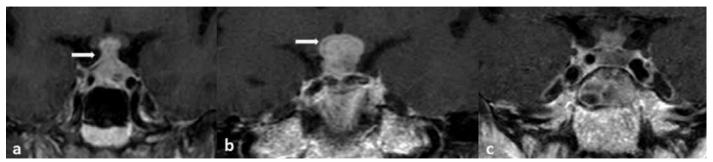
a) Pituitary magnetic resonance imaging of the patient on admission, thickened pituitary stalk (arrow) and heterogenic sellar enlargement, b) magnetic resonance imaging of the recurrent pituitary lesion extending to hypothalamus (arrow), c) magnetic resonance imaging of the pituitary lesion after glucocorticoid treatment
